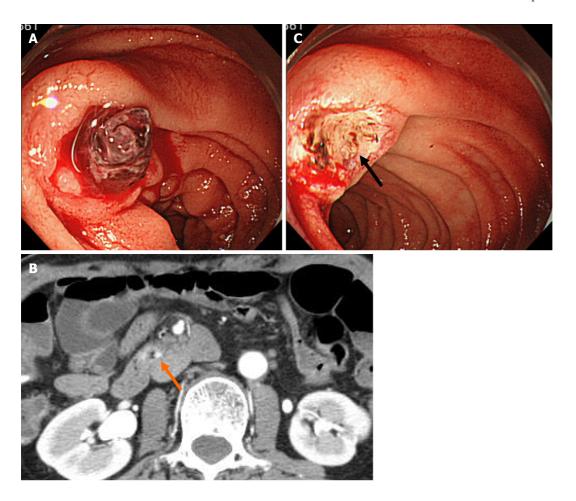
Endoscopic images and abdominal contrast-enhanced computed tomography scan images on initial examination. A: Esophagogastroduodenoscopy showed an ulcerative lesion with fresh blood clots in the transverse part of the duodenum; B: Contrast-enhanced computed tomography scan showed a slight localized contrast effect on the wall of the transverse part of the duodenum (arrow); C: When the blood clots were removed, a protruding vessel was observed at the base of the ulcer (arrow).
